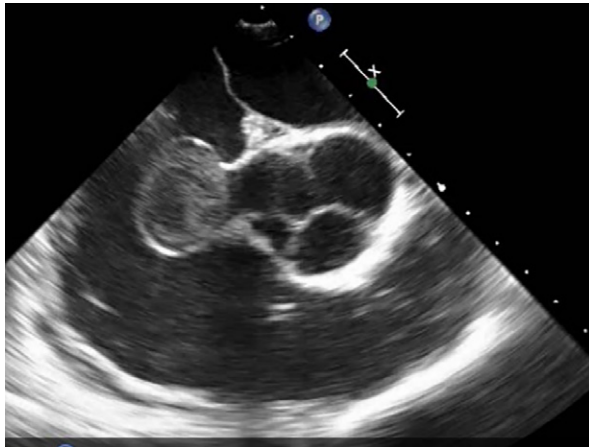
Transesophageal echocardiogram shows no communication between the aneurysmal sac and the cardiac chambers.
